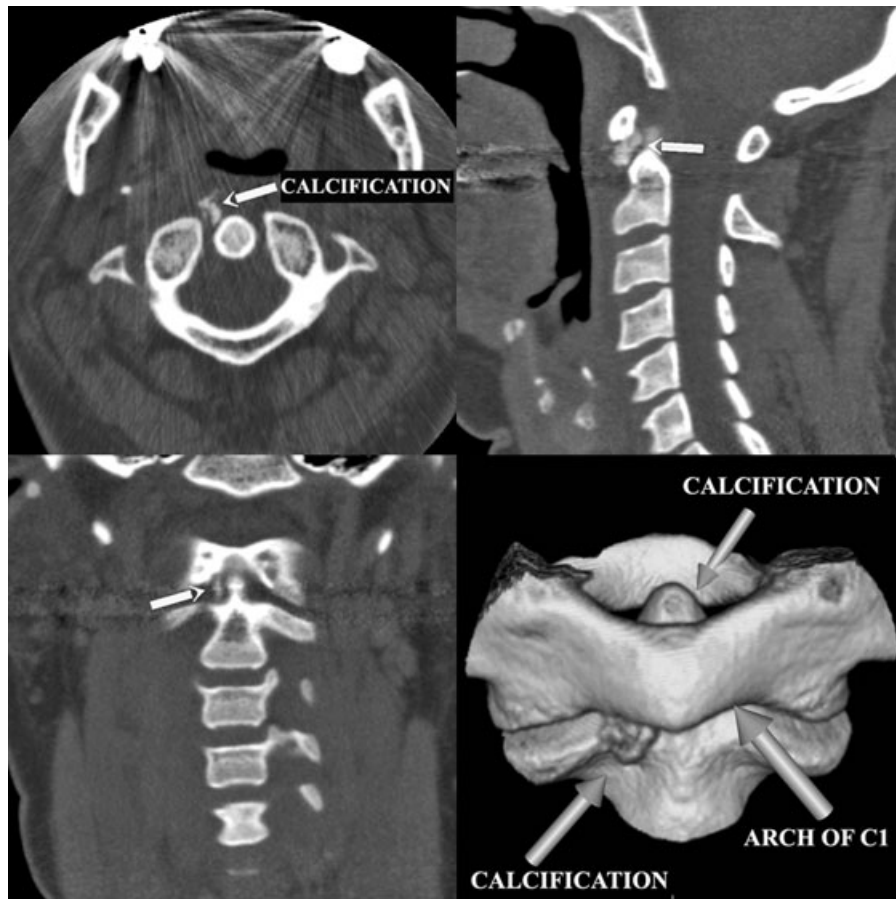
The periodontoid calcifications, displayed in all the three spatial planes in a CT scan of a 39-year-old woman complaining of neck pain and stiffness (arrows), are elegantly demonstrated in a volume-rendered display (lower right image) next to the tip of the dens and adjacent to the anterior atlanto-axial articulation.
